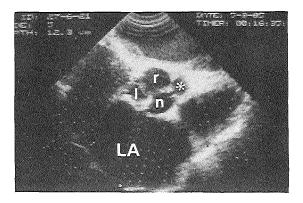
Intraoperative two-dimensional echocardiogram with the right ventricle as point of entrance for imaging a patient with bacterial endocarditis of the aortic valve. The echocardiographic investigation shows an abscess at the commissure between the right (r) and non-coronary (n) aortic valve cusp (asterisk). LA = left atrium; L = left coronary cusp.
